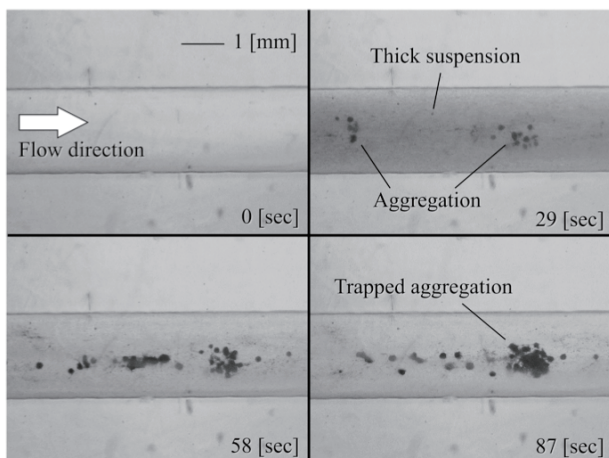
Time series images of the observed area after injection of the suspension with ultrasound emission.
